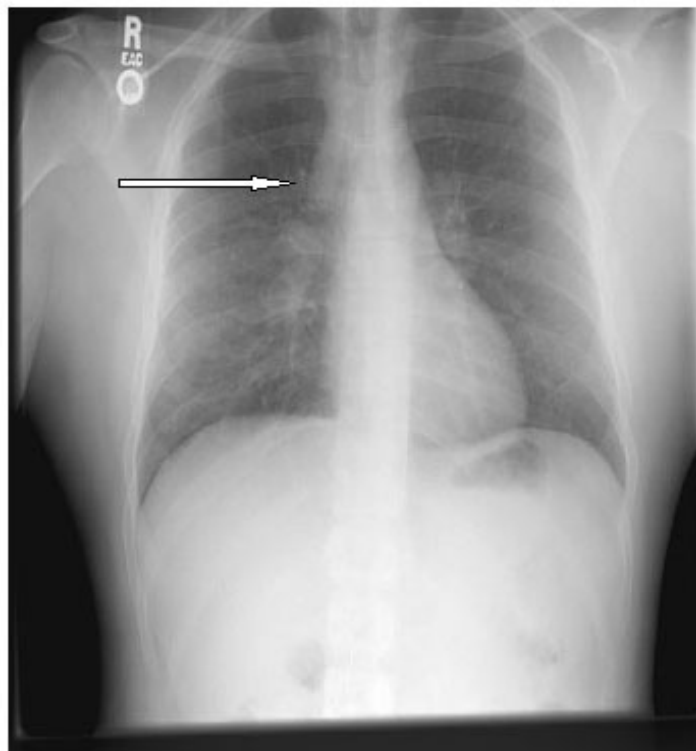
Chest Radiograph for Case 1, Demonstrating Pretracheal Lymphadenopathy (arrow) and Parenchymal Nodular Disease Suggestive of Sarcoidosis.
